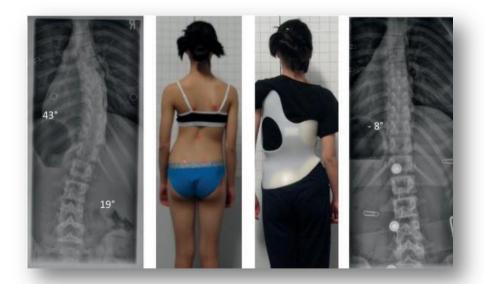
In digital x-ray, through direct radiography (DR), the necessary region (Region of Interest/ROI) for children and adolescents can now almost always fit onto a DR plate using optimal settings. In doing so, exposure to radiation outside the ROI is eliminated. Left, patient without brace clinically and radiographically with a 43° curve; right, patient in the brace with full correction of the curvature. Reduction of the diagnostic field did not reduce the necessary information on either x-ray.
